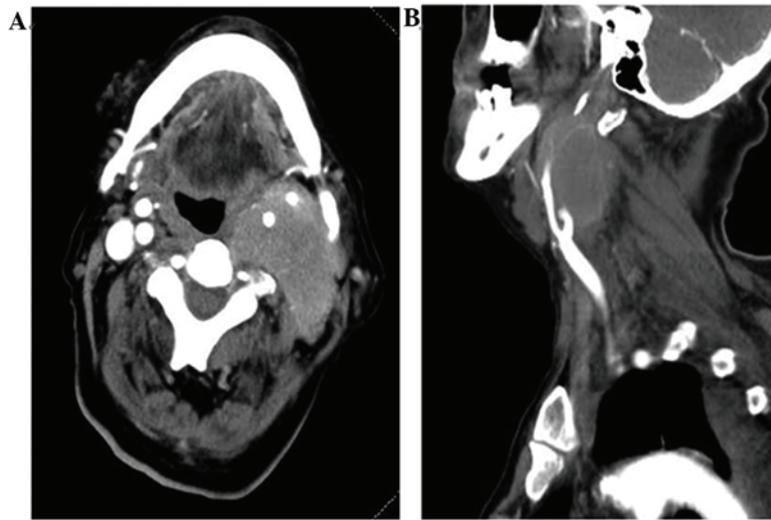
A computed tomography angiography scan of the head and neck revealed a soft tissue mass (A) in the left submandibular area and (B) in the neck, at the level of the left carotid bifurcation and above. The left common carotid artery bifurcation and internal and external carotid artery segments were embedded in the mass.
